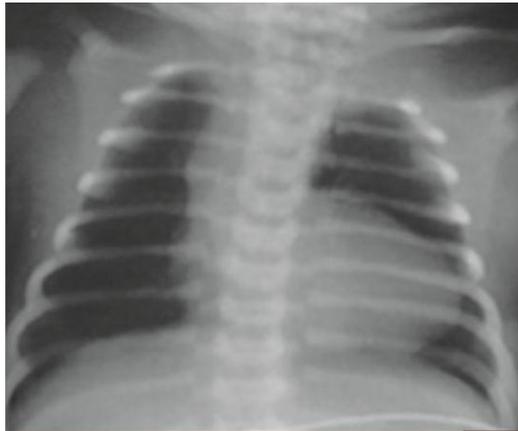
Chest X-ray showing boot shaped heart (*Coeur en sabot*) characteristic of tetralogy of Fallot in a 3 month old infant. Note the decreased pulmonary vascularity and absent PA (pulmonary artery) shadow in the superior mediastinum with leftward shift of ventricular apex due to RV hypertrophy.
